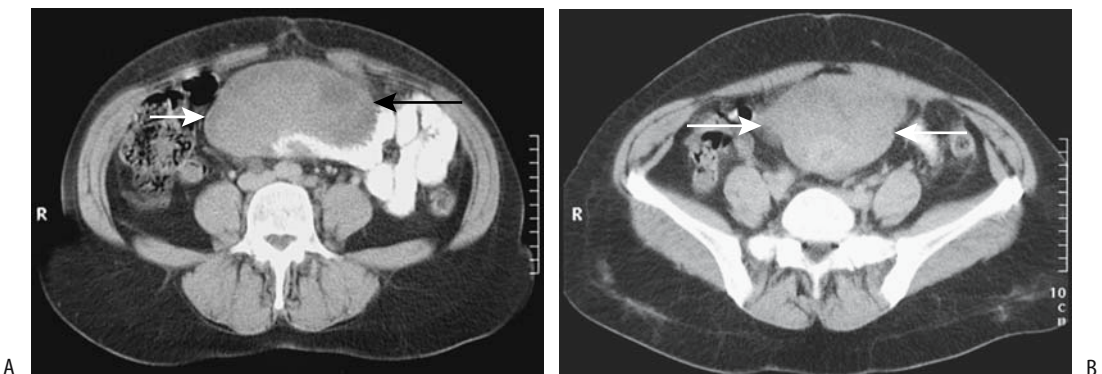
Poorly differentiated mesenteric sarcoma. A,B: Two CT images show a homogeneous midabdominal tumor (arrows) displacing contrast-filled small bowel loops. (Courtesy of Algidas Basevicius, M.D., Kaunas Medical University, Kaunas, Lithuania.)
